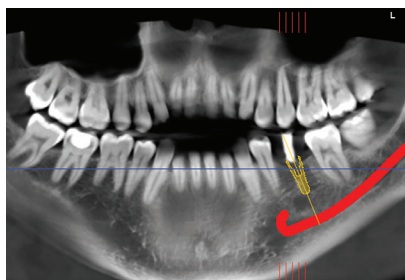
The stent is used with a radiographic marker in the prepared hole for pilot drill. This can then be used with CBCT scan to assess the available bone below the planned tooth replacement.
